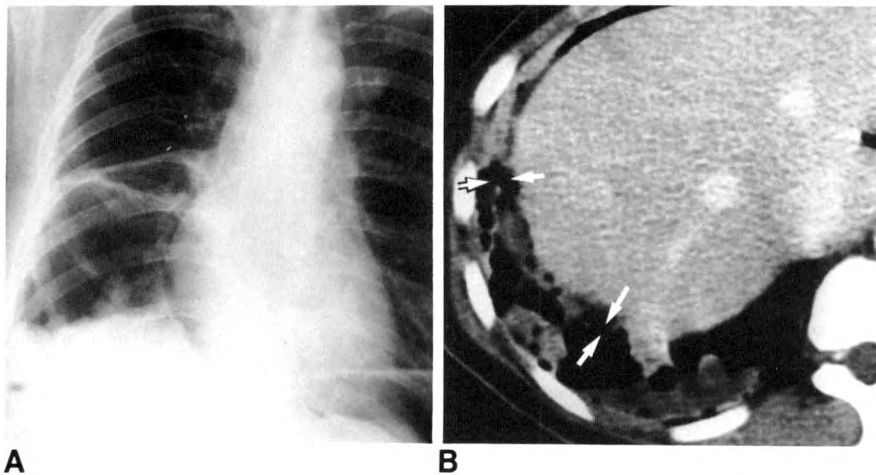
Radiologic findings 2 months after bilateral salpingo-oophorectomy. Plain chest radiograph (A) and CT scan (B).
